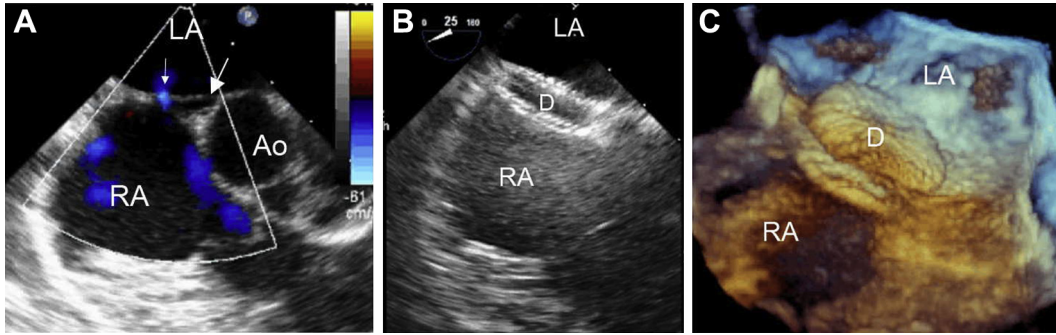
(A) Two-dimensional (2D) transesophageal echocardiography (TEE) view demonstrated a patent foramen ovale (PFO) (large arrow) and an atrial septal defect (ASD) (small arrow); (B) a 24 mm Amplatzer PFO occluder device was implanted; and (C) 3D TEE demonstrated proper placement of the device with adequate coverage of all rims of the interatrial septum. Ao = aorta; D = Amplatzer PFO occluder device; LA = left atrium; RA = right atrium.
